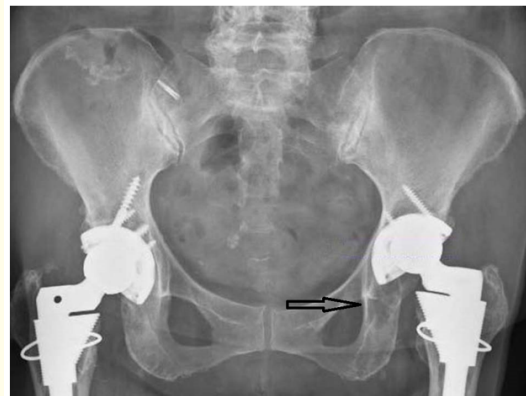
Pelvic radiograph demonstrating left hip prosthesis and areas of a lytic lesion (arrow).
